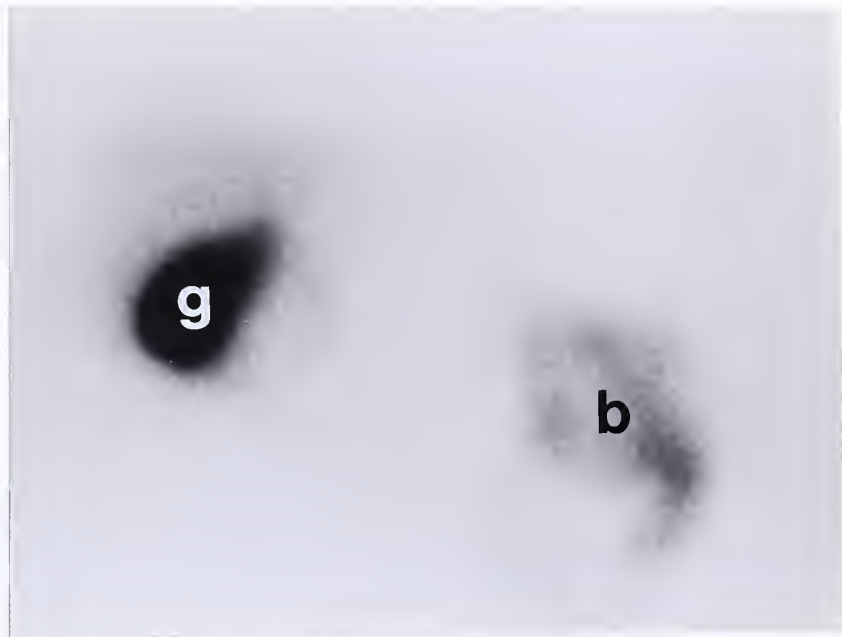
(cont.) Subject #3: (C) Delayed (90 minute) cholescintigraphic image, showing tracer in the gallbladder (g) and bowel (b).
